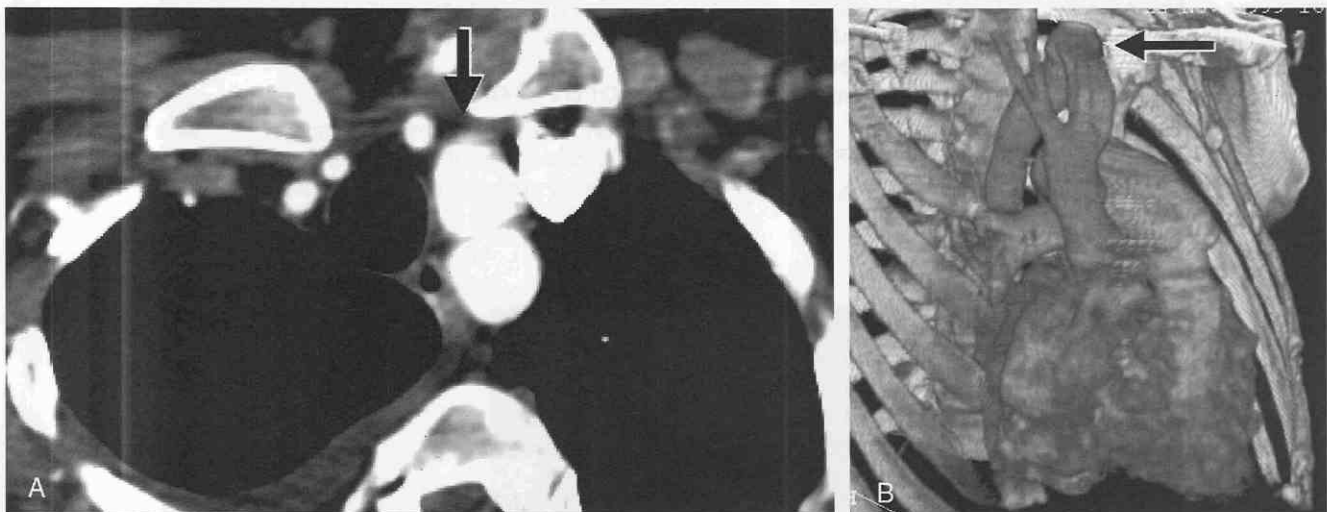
A, Axial CT scan in a patient with a pulsatile neck mass shows aortic arch at the level of the clavicles (arrow). B, Volumetric reconstruction demonstrates the position of the thoracic aortic arch at the level of the clavicle (arrow).
